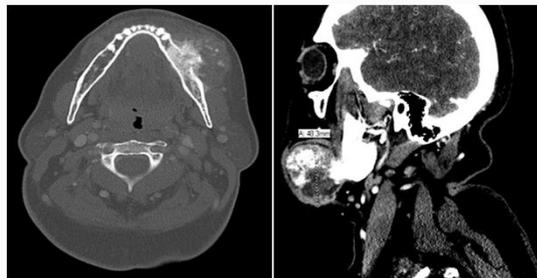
CT demonstrated interval increase of mass (4.4x4.3x4.8 cm) within the left hemimandible with aggressive periosteal reaction and osteoid matrix formation.
